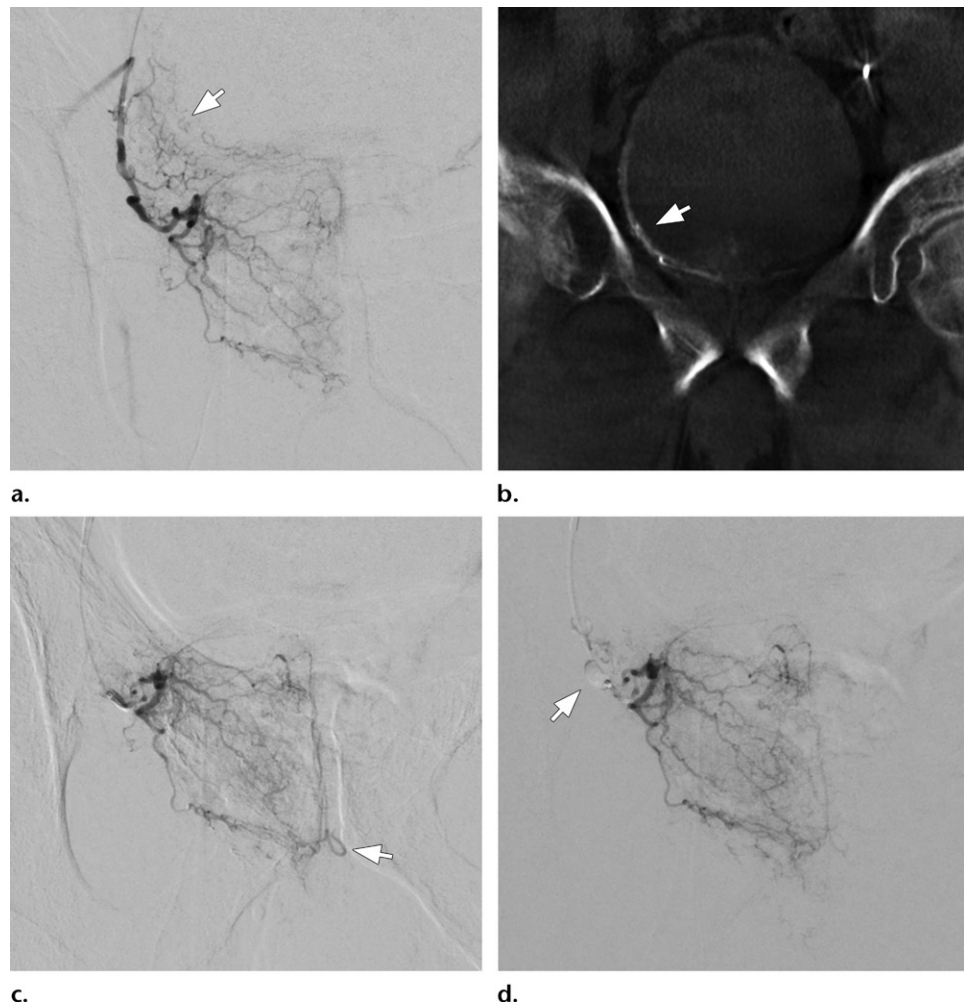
PAE with a balloon occlusion microcatheter. (a) Right PA arteriogram shows perfusion to the right prostate lobe and inferior vesical artery branches (arrow). (b) Coronal cone-beam CT image shows inferior vesical artery supply to the bladder (arrow) risking nontarget embolization. (c) Arteriogram obtained after the microcatheter was advanced distal to the inferior vesical artery shows perfusion to the prostate and an extraprostatic nontarget vessel (arrow). (d) The microcatheter occlusion balloon was inflated (arrow) and arteriography was repeated. The extraprostatic vessel was no longer visualized, which suggested reversed flow toward the prostate. The catheter also protects from reflux into the inferior vesical artery.
